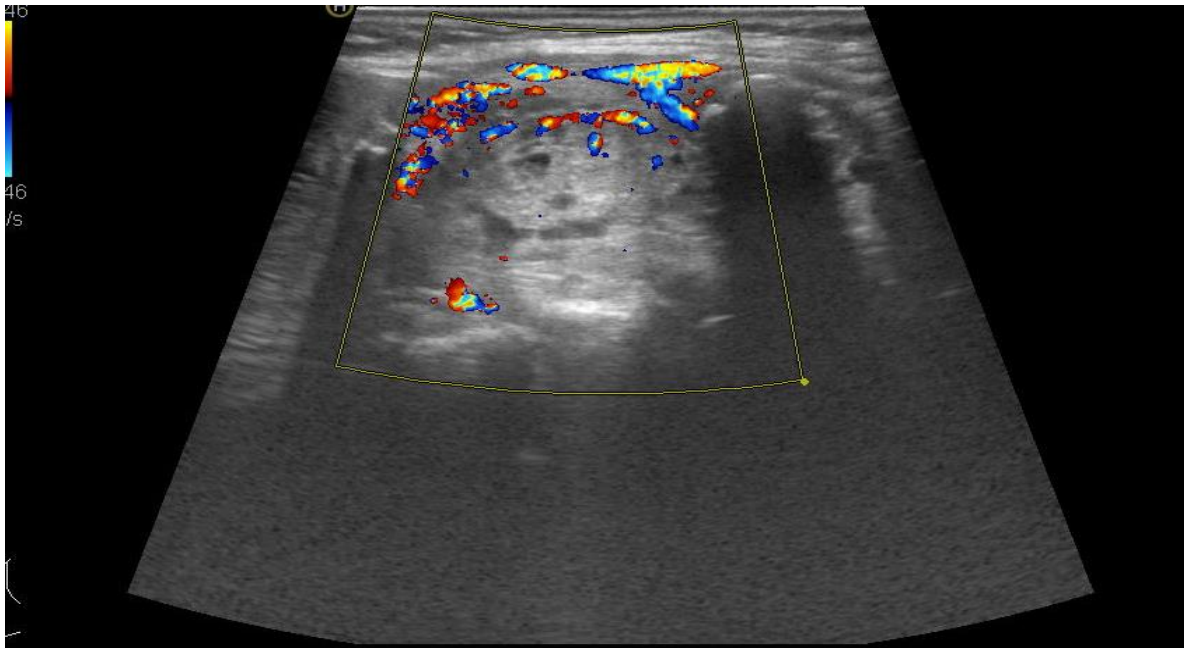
Thyroid cancer. Hypervascularization of the node. In color Doppler mapping mode
